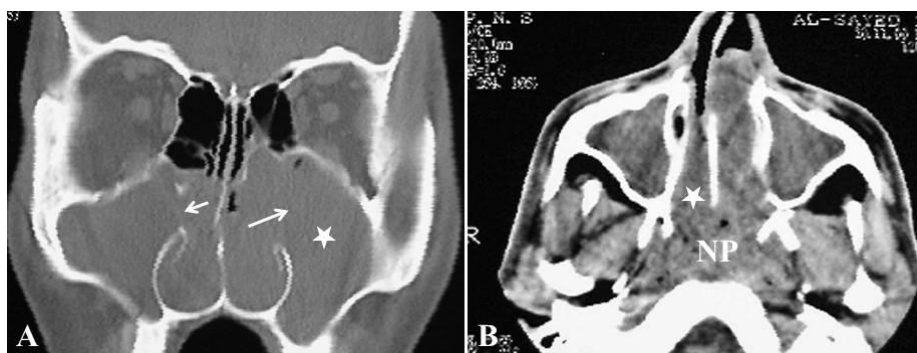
(A) CT scan with coronal bone window cut showing soft tissue density masses filling both maxillary antra and nasal fossae more marked on the left side (white asterisk), with a mild expansion of the left antral roof, and widened maxillary sinus ostia on both sides (white arrows). (B) CT scan with axial soft tissue cut showing soft tissue density masses filling both maxillary antra, with a soft tissue density mass filling the left nasal fossa, extending through the left choana into the postnasal space (NP), then through the right choana into the right nasal fossa (white asterisk).
